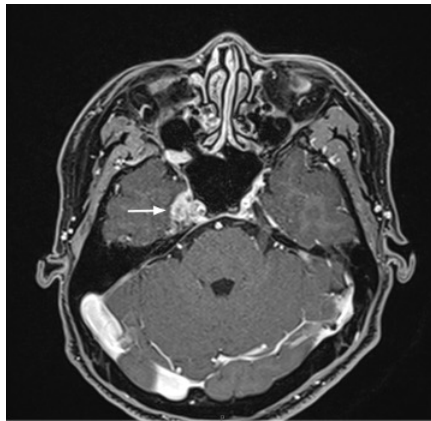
Axial T1 magnetic resonance imaging with intravenous contrast demonstrating a lesion in the right Meckel's cave indicated by the white arrow.
